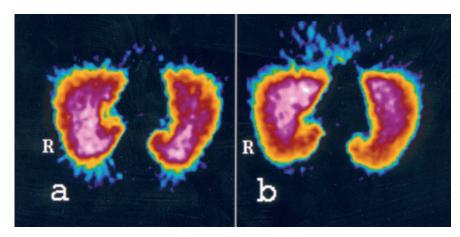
SPECT image of pulmonary perfusion before and after NOS inhibition. SPECT acquisition in a healthy human volunteer before (a) and after (b) administration of the NO synthase inhibitor L-NMMA iv. A horizontal projection is shown with the ventral lung regions facing upwards and the dorsal downwards. The subject was placed in the supine position throughout the procedure, and the basal parts of the lungs are shown. R=right lung.
